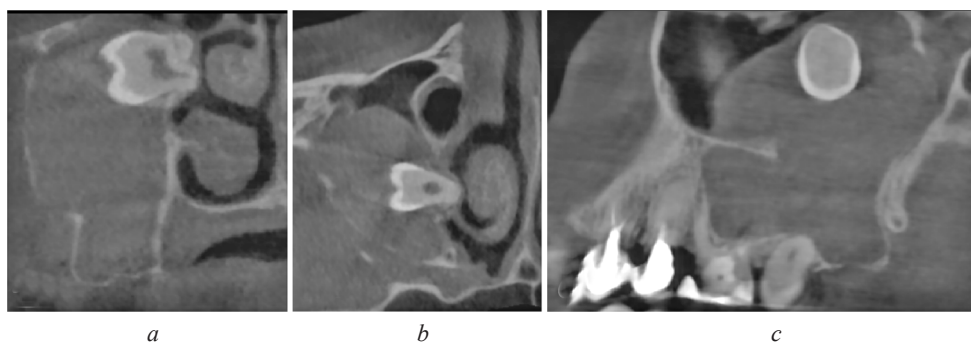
CBCT, coronal (a), axial (b), and sagittal (c) images showing soft-tissue mass occupying almost the entire right maxilla R y sinus and involving ectopic third maxillary molar
